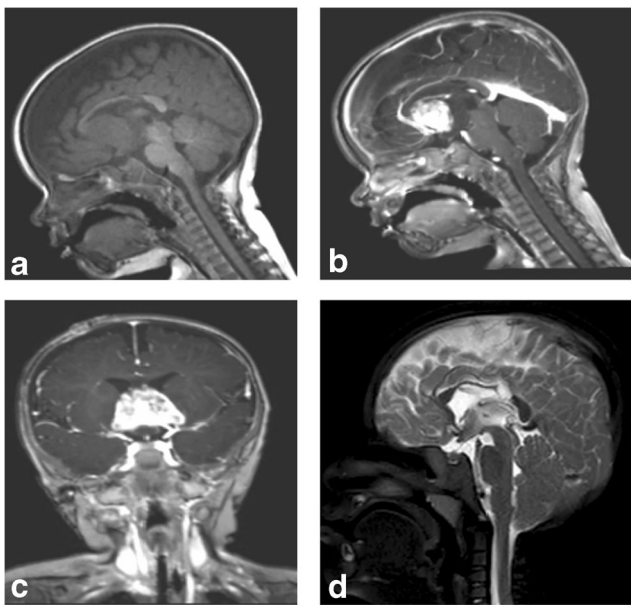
a Preoperative sagittal MRI without contrast demonstrating $5 \times 5 \times 3$ cm tumor of the third ventricle of case reported herein. Note the tumor's upper limit under the genu of the corpus callosum. b Preoperative sagittal MRI with contrast. Note the relationship of the tumor to the anterior cerebral arteries. c Preoperative coronal MRI with contrast. Note the pyramidal shape of the tumor in the coronal plane and suprasellar location. d Follow up T2-weighted sagittal MRI image at 1.5 years follow up noting gross total resection cavity without enhancing tumor
